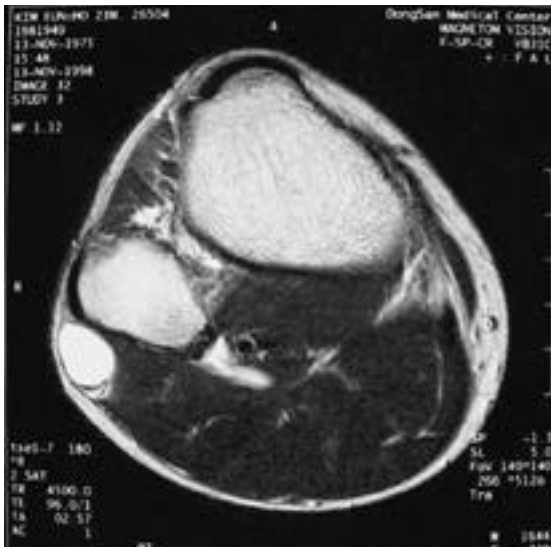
T2-weighted images (TR/TE: 4500/96) at the same level as Fig.1 showing the high signal from the cyst.
